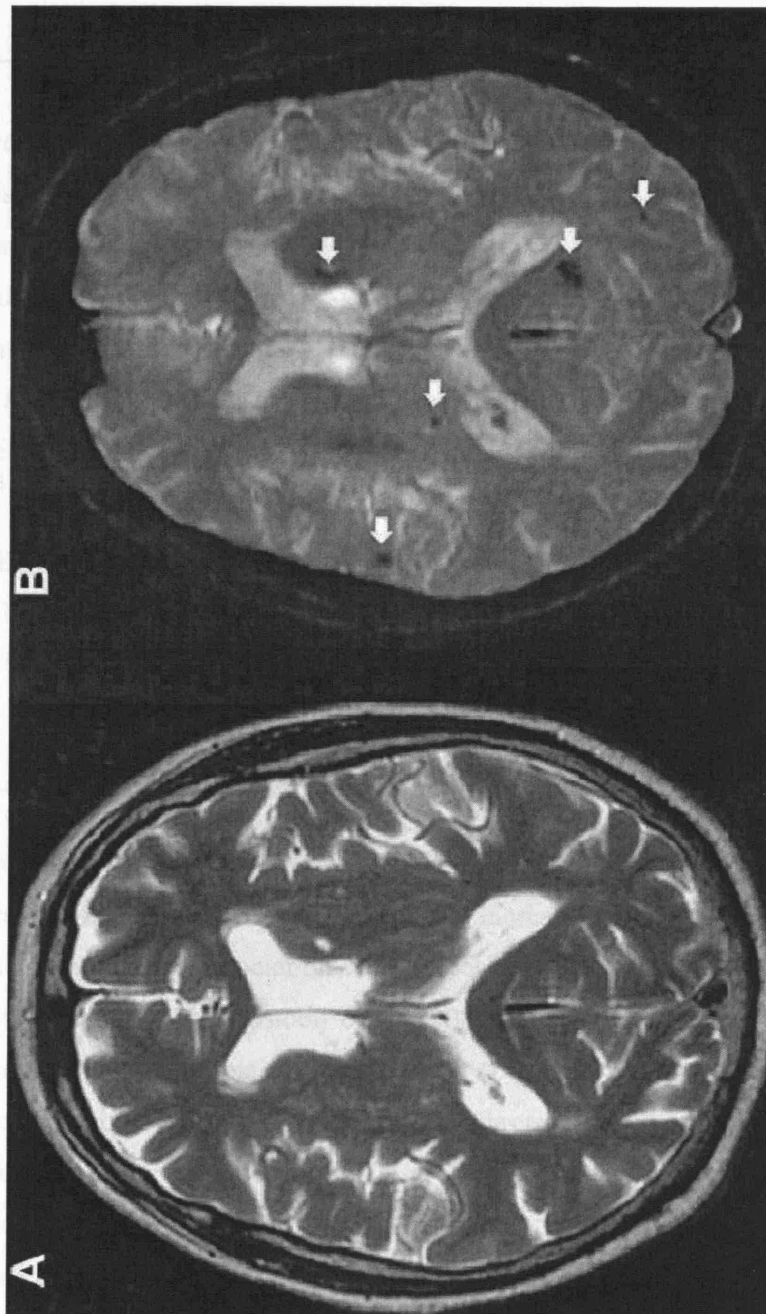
Brain Microbleeds on GRE T2*W MRI
